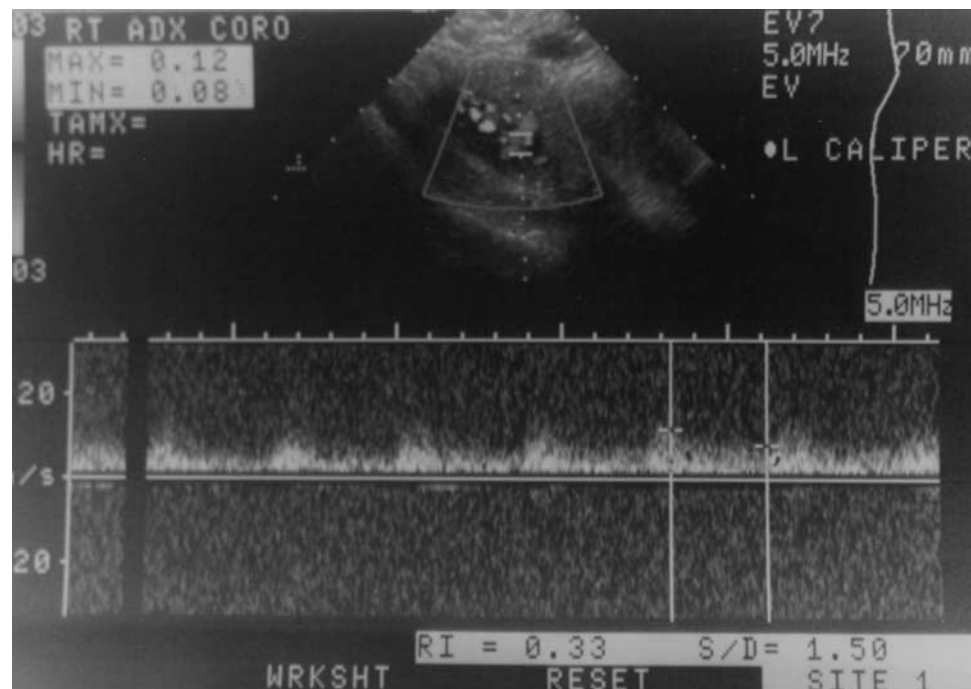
Doppler interrogation of the solid mass seen in Figure 3 displaying a moderately low resistive index.
